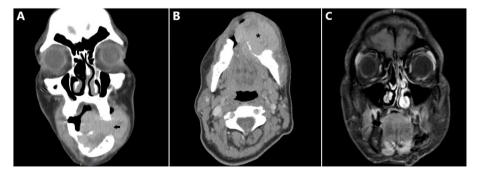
a Coronal view of CT, black arrow showing the destruction of the left mandibular body. b Axial view of CT, * showing destructive mass. c A postoperative coronal T1 MRI image shows that there is no residual contrast-enhanced lesion after surgery
